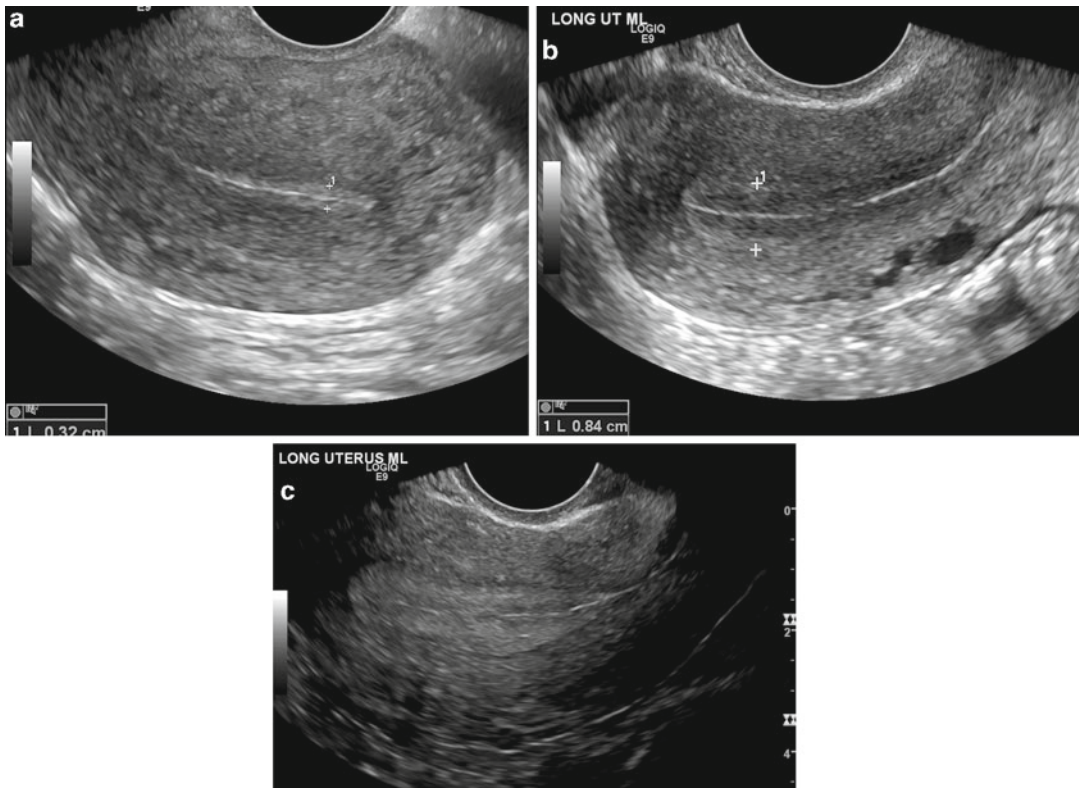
Transvaginal sonographic images of the premenopausal endometrium. (a) Menstrual phase. (b) Proliferative phase. (c) Secretory phase
